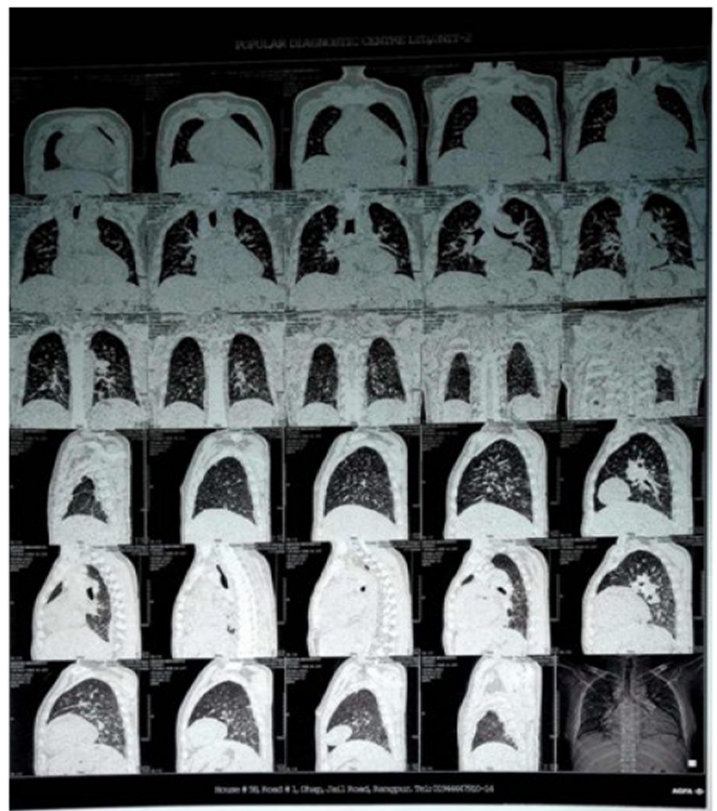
Computed tomography (CT) scan of the chest showing diffuse areas of increased density/sclerosis with reticulonodular changes and thickening of the interstitium.
